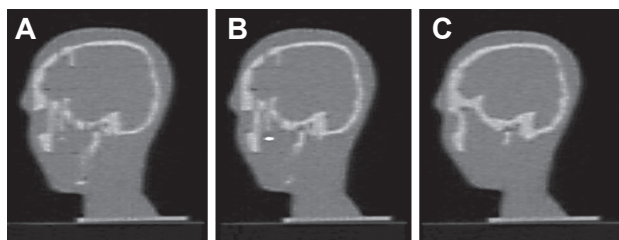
Sagittal CT slices taken at level -3.9 cm (A), -4.1 cm (B) and -4.2 cm (C).
